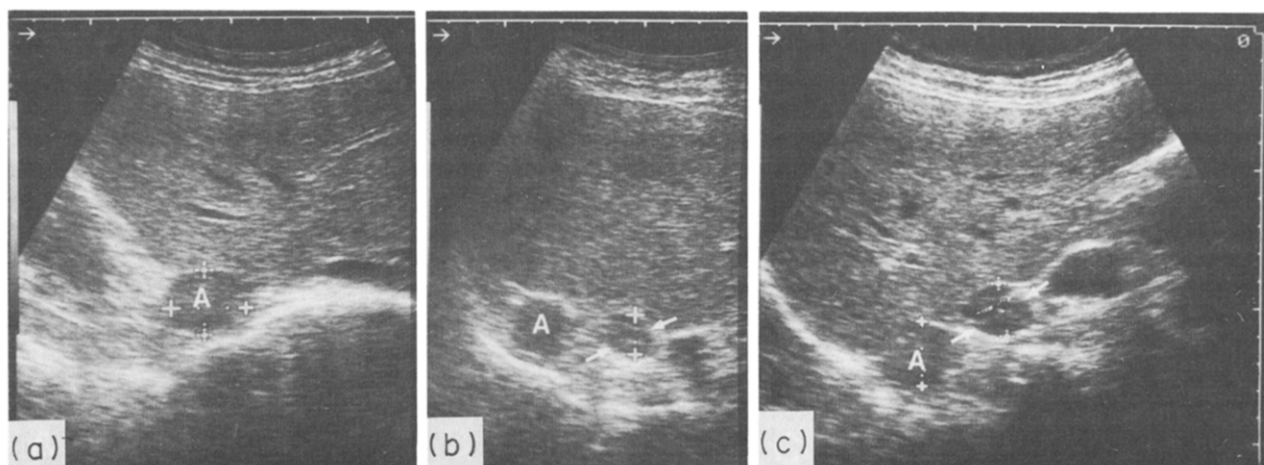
Initial intercostal sonogram (a) in a patient with lung cancer shows large predominantly round, homogeneous, hypoechoic adrenal tumour. Follow-up examination 2 (b) and 6 months (c) later revealed tumour progression. m = metastasis, l = liver.
